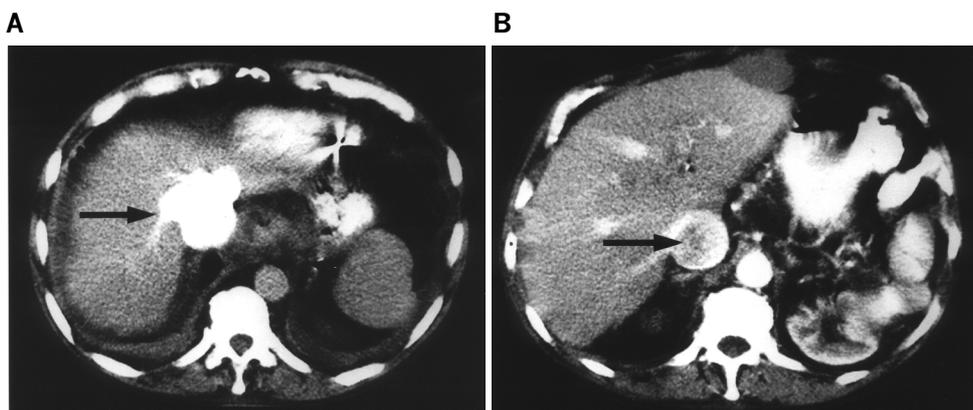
(Patient 1). CT of the upper abdomen; intravenous contrast material was delivered by an automatic injector. [A] Dense enhancement of dilated inferior vena cava (arrow) and hepatic veins occurring prior to aortic enhancement. [B] After 15 seconds, the branches of the hepatic arteries are already visible, while hepatic veins are still enhanced by retrograde filling. A filling defect ("pseudothrombus") is seen in the IVC (arrow) due to the flow of non-enhanced blood into the previously opacified IVC.
